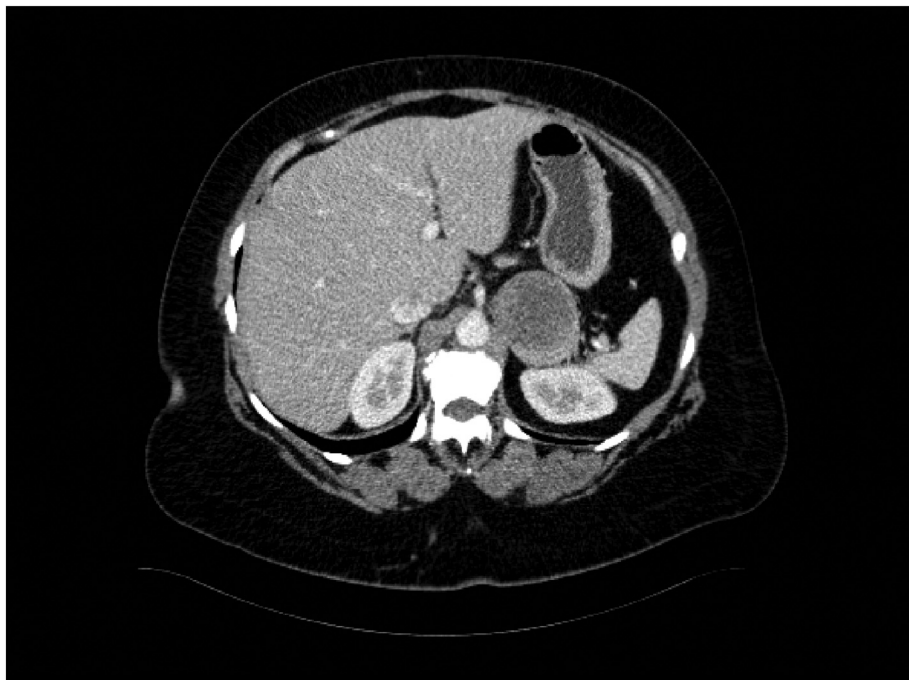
CT image showing a left adrenal mass with peripheral enhancement and central necrosis.
